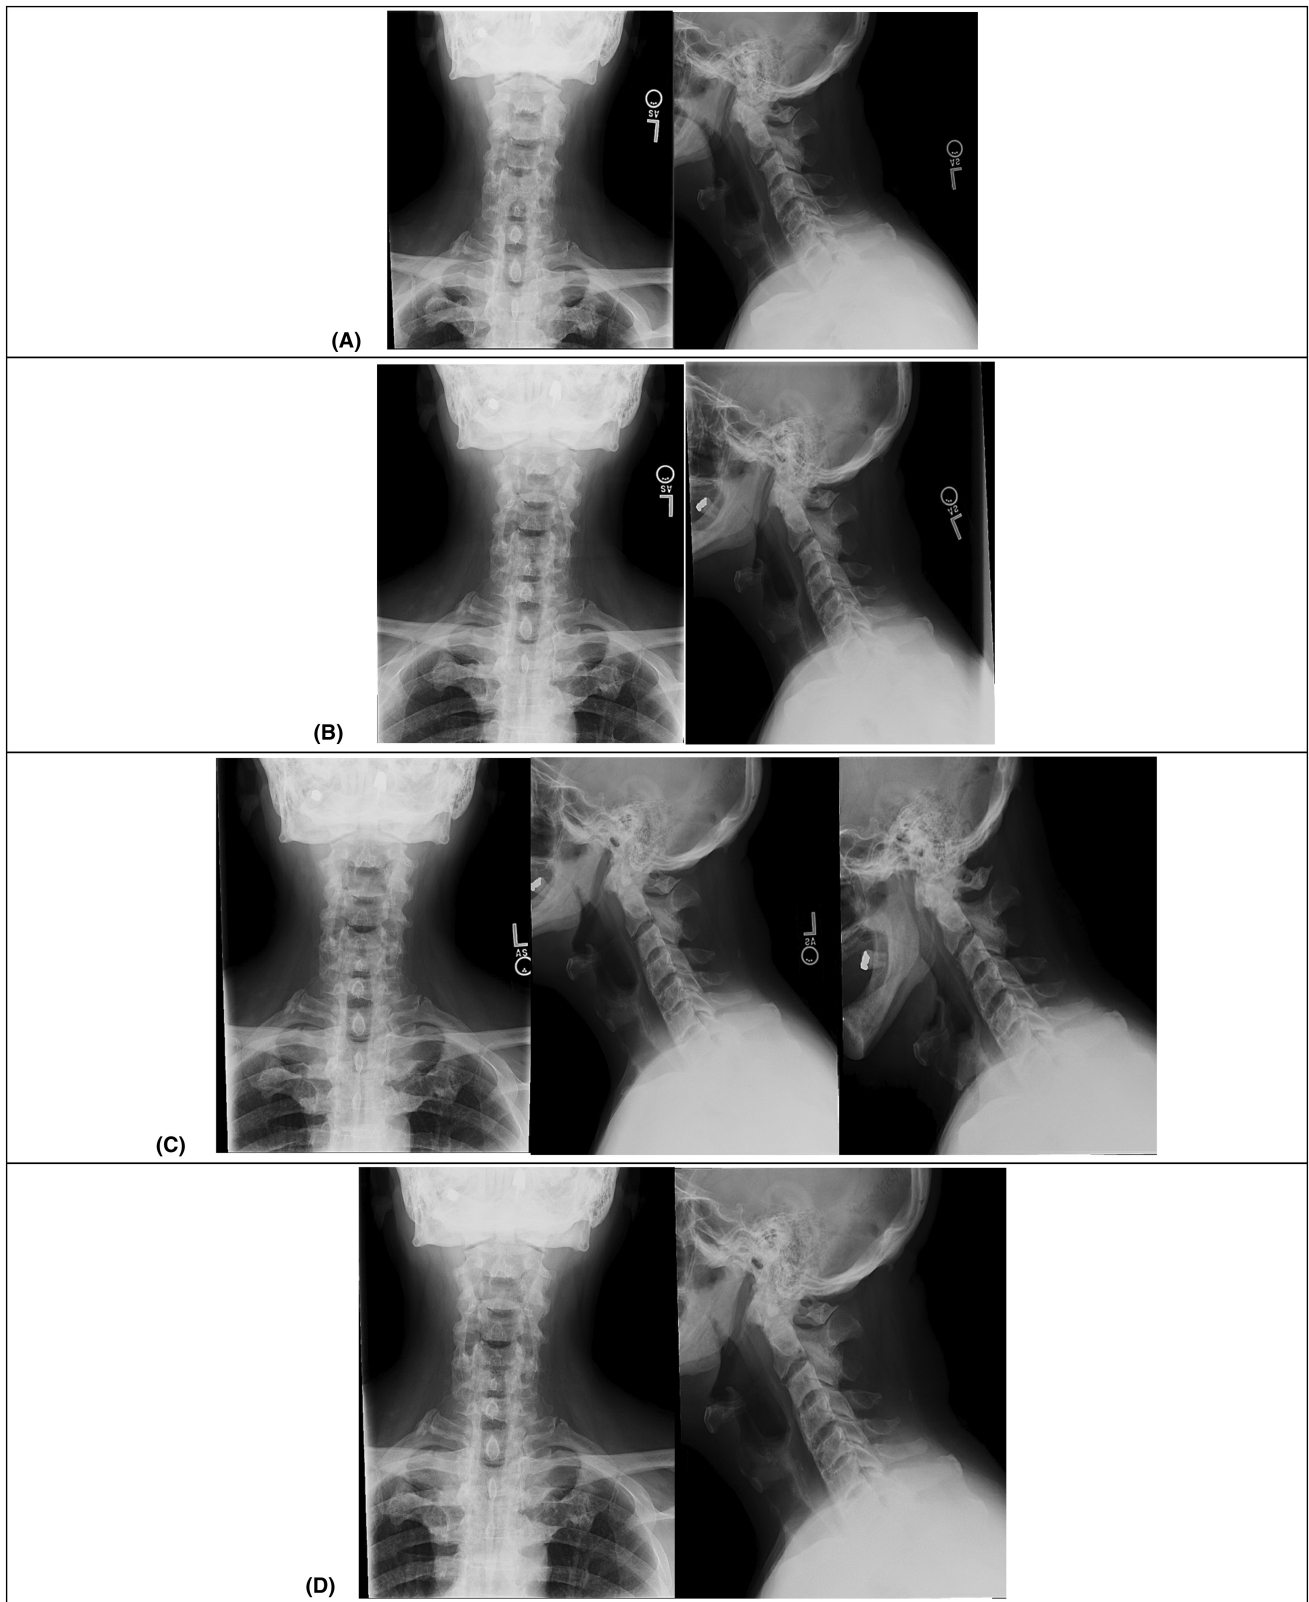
Post-operative visit (POV) radiographs. (A) POV 1 (2 weeks) (B) POV2 (3 months) (C) POV 3 (6 months) (D) POV 4 (1 year).
